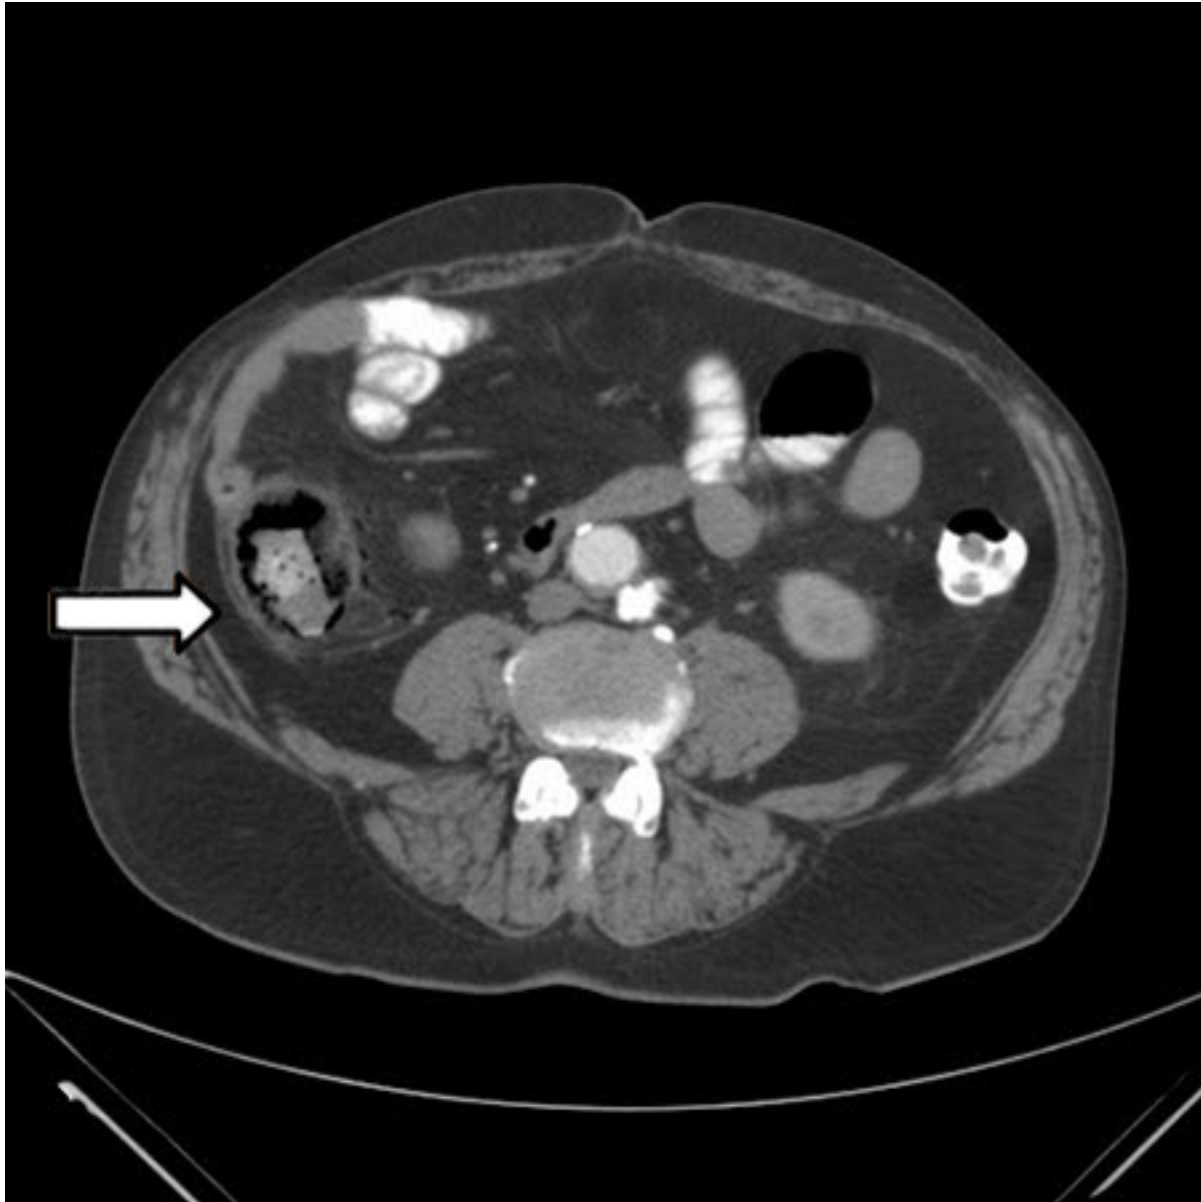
Ischaemic bowel disease: CT scan showing colonic thickening with pneumatosis intestinalis
